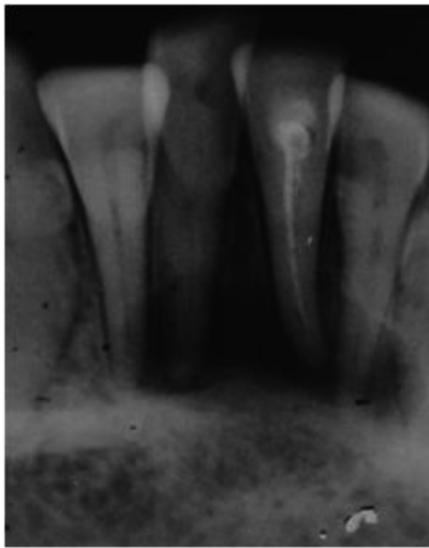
Pre-operative Radiograph wrt 31, 32, 41, 42 showing large periapical lesion and poor obturation wrt 31
